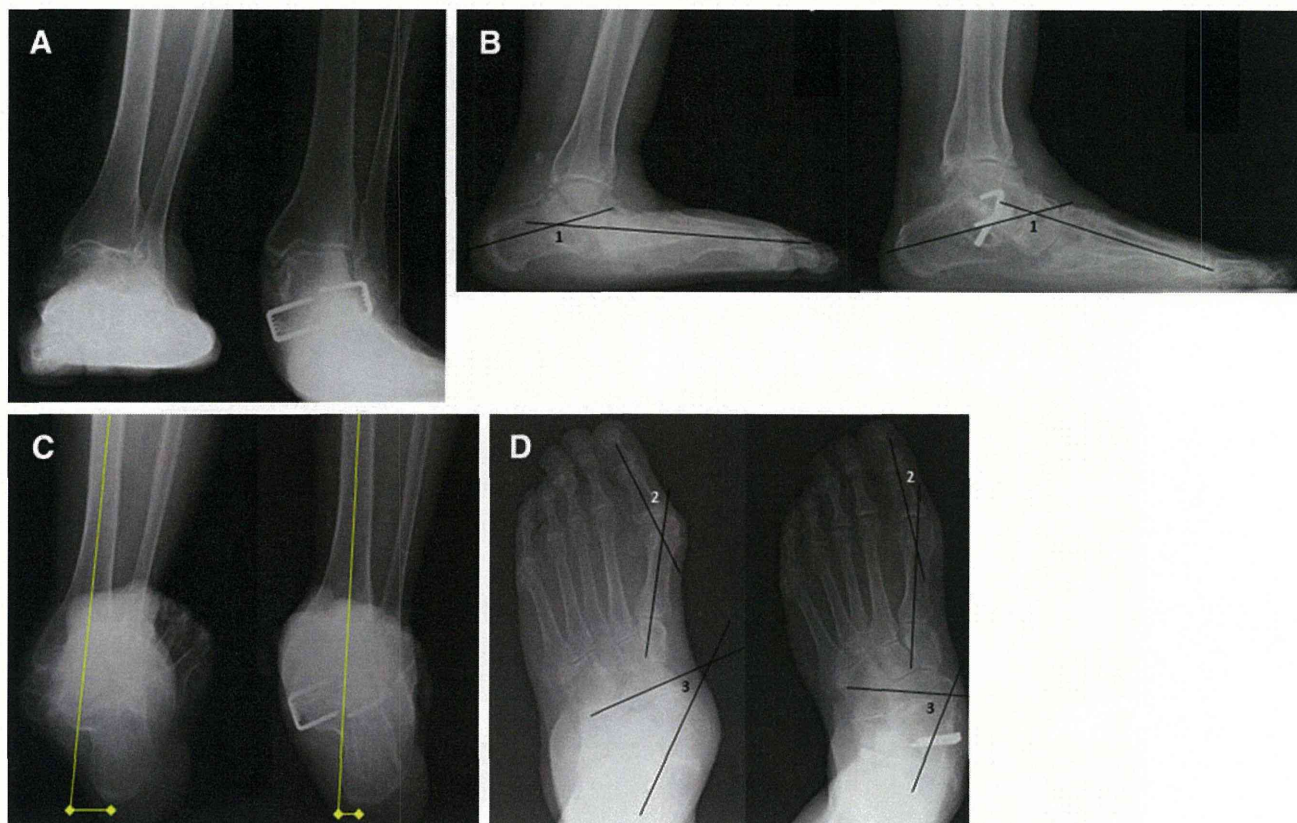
In all of the X-ray images presented here, the *left panel* shows the preoperative status and the *right panel* shows the postoperative (4 months after surgery) status. A 64-year-old woman with severe pain of the valgus hindfoot including the subtalar and talonavicular joints underwent subtalar and talonavicular joint arthrodesis to achieve as much correction as possible. a Anteroposterior (AP) view of the ankle joint in the standing position. b Lateral view of the ankle joint in the standing position. The IA angle improved from 161° to
